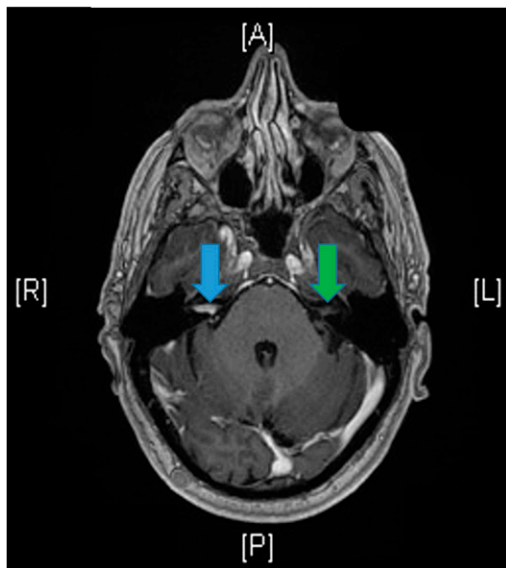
T1-weighted MRI with gadolinium contrast in the axial plane at the level of the IAC. The blue arrow points to enhancing intracanalicular VS on the right that was measured to be 9 mm. The green arrow points to nonenhancing IAC on left. [A] = anterior, [P] = posterior, [R] = right, and [L] = left. (This figure appears in color in the online version of this article.)
